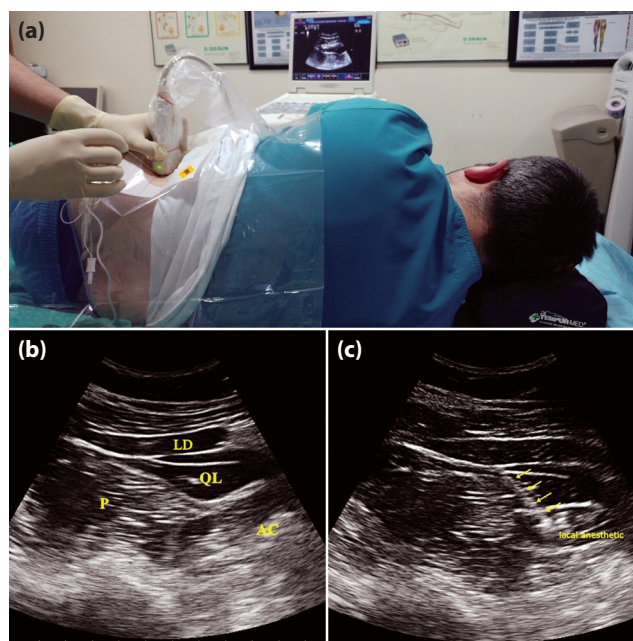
(a) Probe and ultrasound set up for QL block. (b) Sonographic anatomy of block. (c) After local anesthetic administration. LD: Latissimus dorsi muscle; QL: Quadratus lumborum muscle; P: Psoas muscle; AC: Abdominal cavity; Yellow arrows: Needle.
